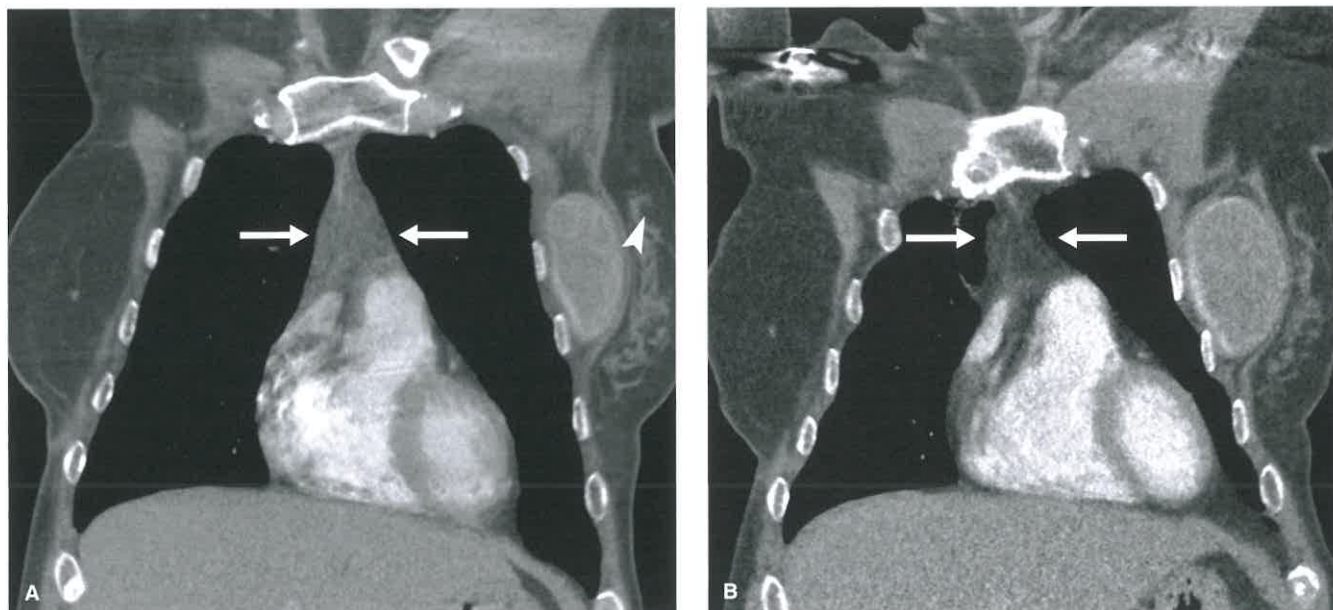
Thymic Hyperplasia. A: Coronal contrast-enhanced CT through the anterior mediastinum in a 55-year-old woman who recently completed chemotherapy for left breast cancer shows a diffusely enlarged thymus (arrows) with predominantly soft tissue attenuation. Note left breast prosthesis (arrowhead). B: Coronal CT scan years later following completion of chemotherapy shows a decrease in size of the thymus (arrows) with almost uniform fat attenuation.
